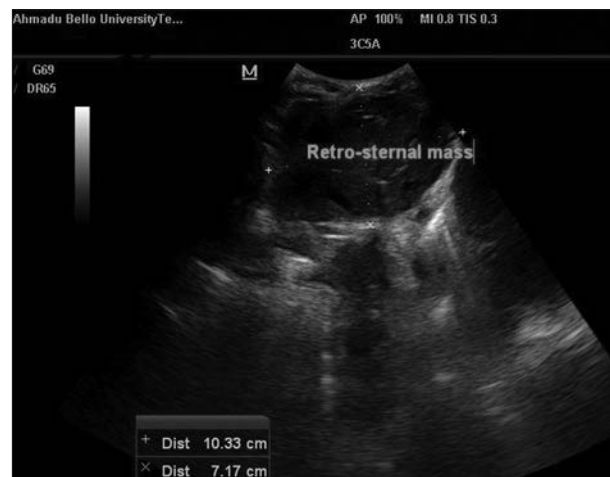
Ultrasonogram through the suprasternal approach, showing a lobulated mixed echogenic retrosternal mass, measuring 10.3 cm × 7.2 cm in dimension (original image)
